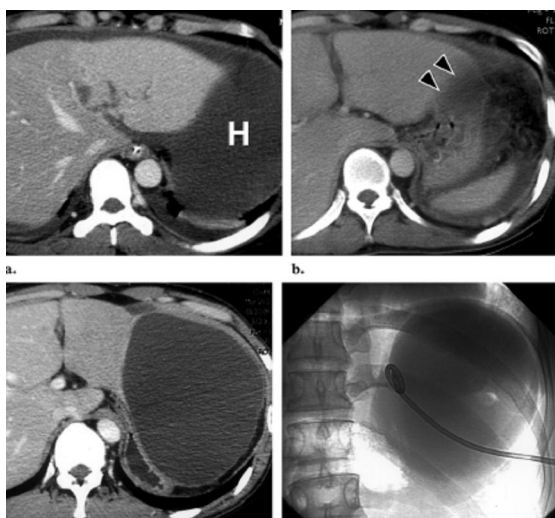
Biloma. (a) Initial contrast-enhanced CT scan shows lacerations in the left hepatic lobe. Note the extensive hemoperitoneum (H). (b) Follow-up contrast-enhanced CT scan obtained 1 week later reveals complete resolution of parenchymal injury. A small amount of hemoperitoneum persists in the left perihepatic space (arrowheads). The patient presented with fever and left upper quadrant pain 2 weeks after blunt liver trauma. (c) Follow-up contrast-enhanced CT scan reveals a large cystic lesion that had developed in the left upper abdominal cavity. (d) Radiograph obtained during percutaneous catheter drainage which reveals a noninfected bile collection.
